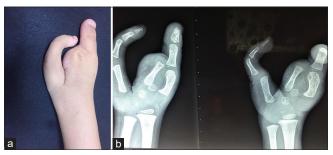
(a) Atypical cleft right hand with absent second, third, and fourth digits and deformed fifth digit with preserved thumb opposition and adequate grasp. (b) X-ray of the right hand and wrist revealed absent third and fourth ray and absent phalanges of the second finger with four malformed carpals with carpometacarpal dislocation
